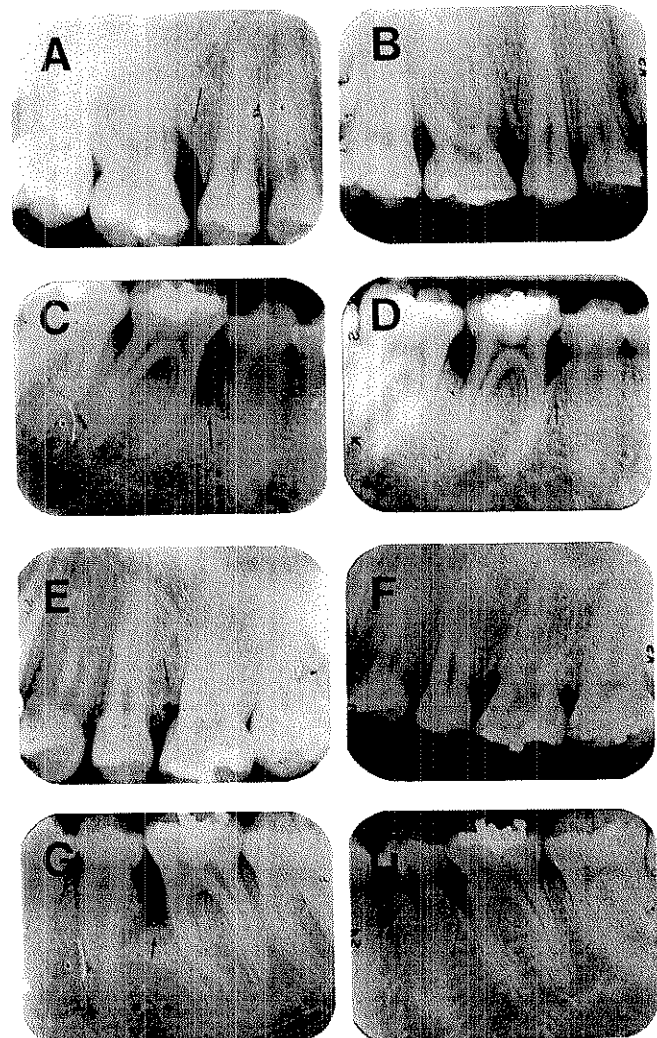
A,C,E,G. Case #3, radiographs with associated vertical defects, January 1979. B,D,F,H. Case #3, radiographs with resulting bone fill, February 1983.
